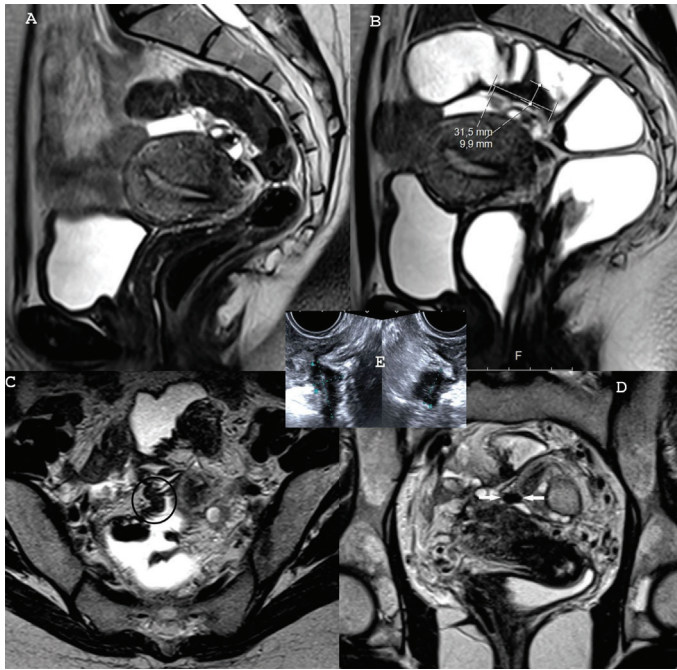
A) Sagittal T2W image of patient 2 in the previous magnetic resonance imaging MRI scan. It is not possible to detect the actual place of the intestinal involvement, B) Sagittal T2W image of patient 2 in the present MRI scan. The intestinal involvement of the endometriosis in the sigmoid bowel, which was measured, can be detected easily, C) Axial T2W image of patient 2 in the present MRI scan. The lesion is measured in a horizontal plane, D) Coronal T2W image of patient 2 in the present MRI scan. The lesion is measured, E) Transvaginal ultrasound in patient 2. The endometriotic intestinal nodule is measured. The nodules due to the hypertrophy and the fibrosis of the muscular propria grow into the lumen and narrowing the diameter. The nodule has a comet shape with a tail; comet sign
